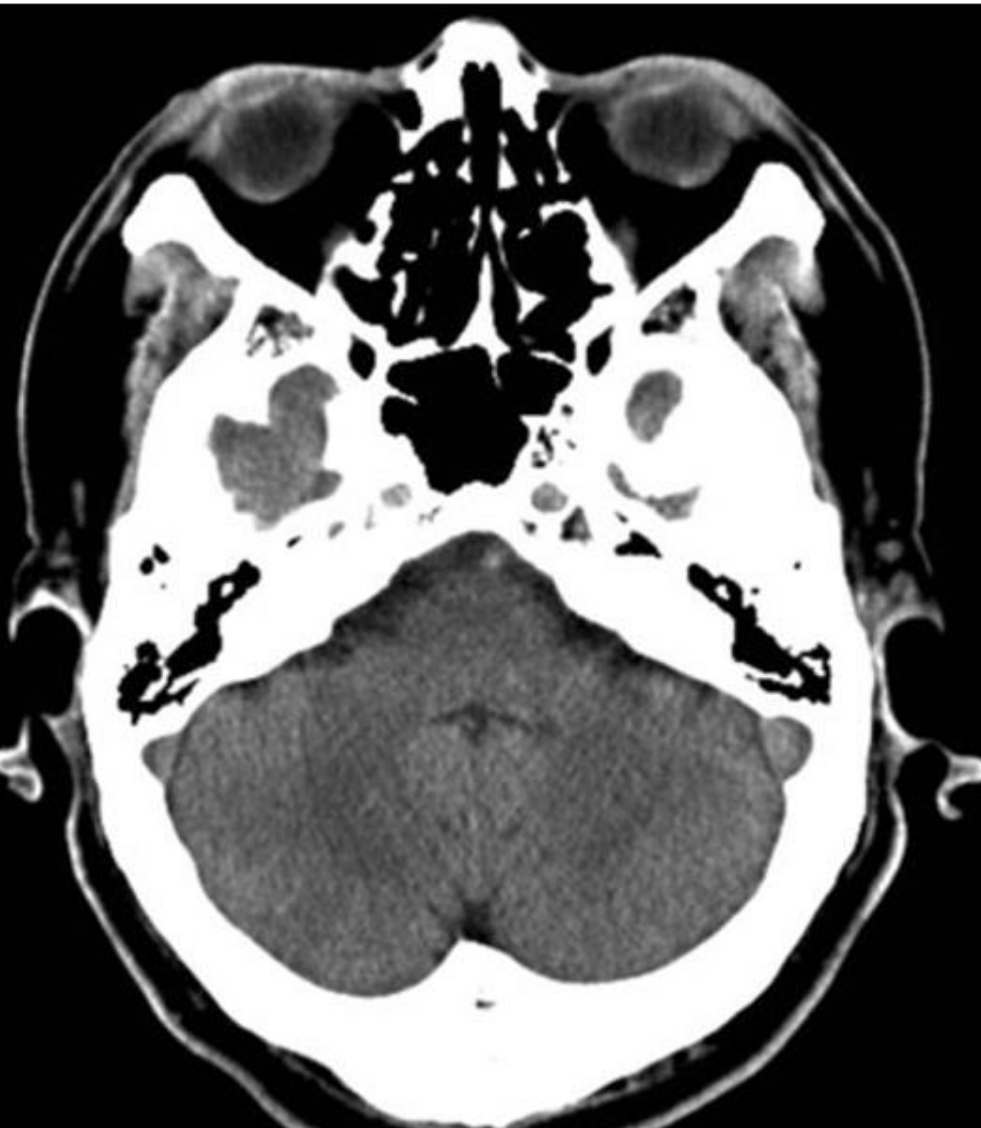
The cranial CT scan of the brain and skull on the initial day was normal
